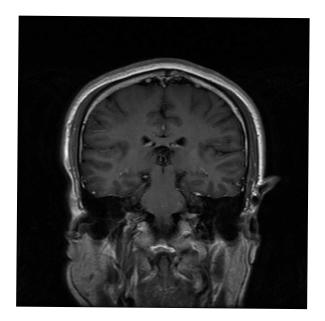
Brain MRI showed no obvious abnormalities, T1 weighted image coronal view.
